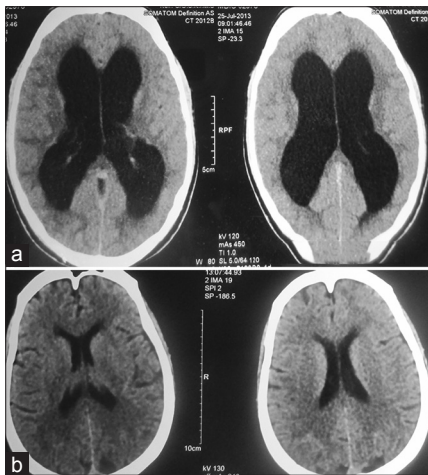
Computed tomography scan axial sections show hydrocephalus (a), postoperative third ventriculostomy ventricle size has reduced (b)
